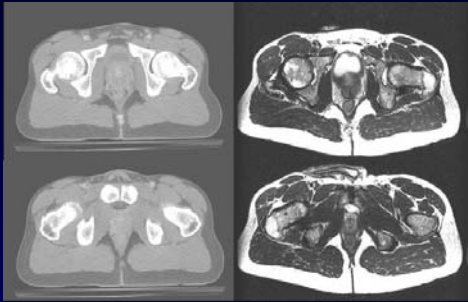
CT (left) and MR slices through approximately corresponding sections near the middle (above) and apex (below) of the prostate. Image parameters: CT, 5mm slice thickness, single-slice axial acquisition mode, 0.78 mm pixel size; MR, 4.5 mm slice thickness, 0.74 mm pixel size.
